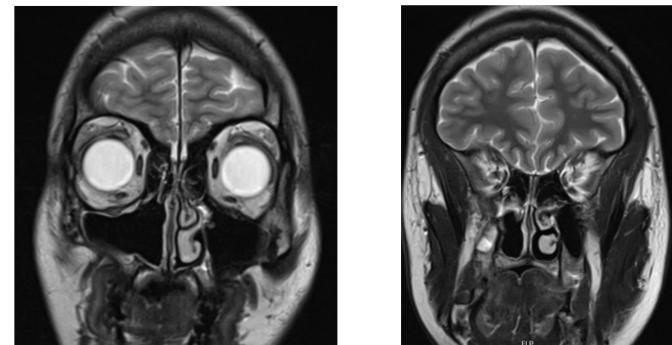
6-month post-operative T2 weighted MRI showing no residual tumor
